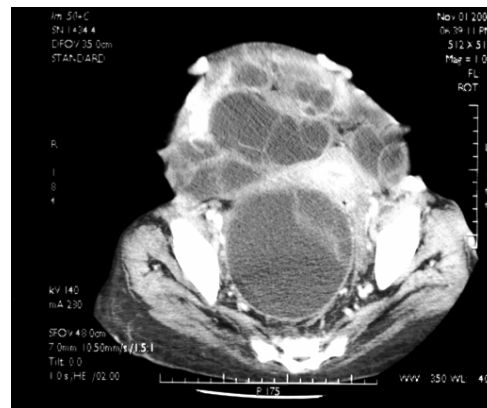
Enhanced CT of the Abdomen. Multiple well defined mesenteric cysts with septae
